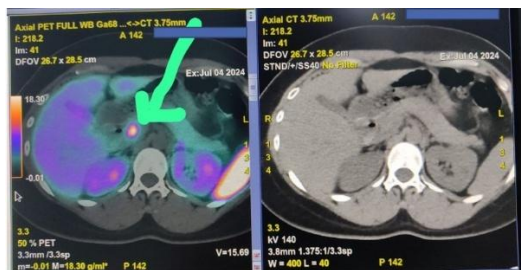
a ^{68}Ga -DOTATATE PET/CT shows suggestive a insulinoma at head of pancreas
